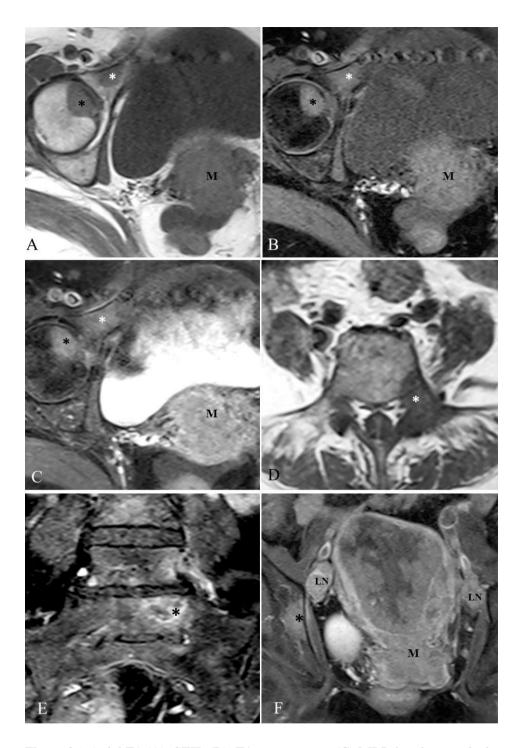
Axial T1 (A), STIR (B), T1 post-contrast (C) MRI showing cervical mass (M) withT1 hypo, STIR hyperintense and heterogeneously enhancing metastatic lesion in the head of femur (black asterisk *) and superior pubic ramus on right side (white asterisk *). Axial T1 (D) and coronal STIR (E) MRI showing metastatic lesion in pedicle, lamina of L5 (black asterisk *) and body of S1 vertebra on left side. Coronal post-contrast T1 fat saturated (F) MRI showing heterogeneous enhancement of the cervical mass (M) with heterogeneously enhancing metastasis to right iliac bone (black asterisk *) and bilateral internal iliac chain lymph nodes (LN).
